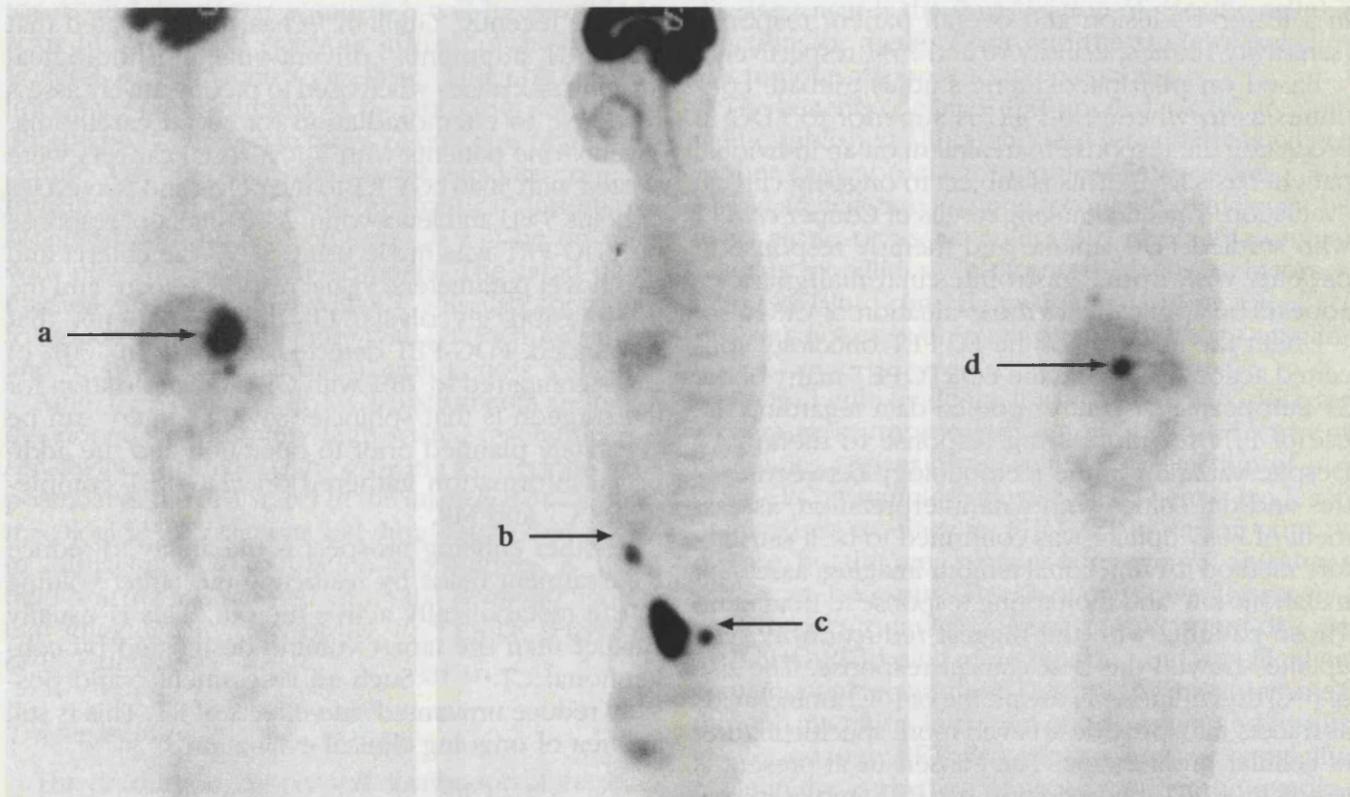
A-C) Sagittal FDG-PET study in a patient referred for assessment of a solitary liver metastasis. FDG-PET, however, demonstrated lesions in the liver (a and d) as well as pelvic (c), and anterior abdominal wall (b) disease. This is an extreme example, but in certain patients with local recurrence, the detection of additional metastatic lesions suggests disseminated disease, poor prognosis and therefore contraindicates surgical resection.
